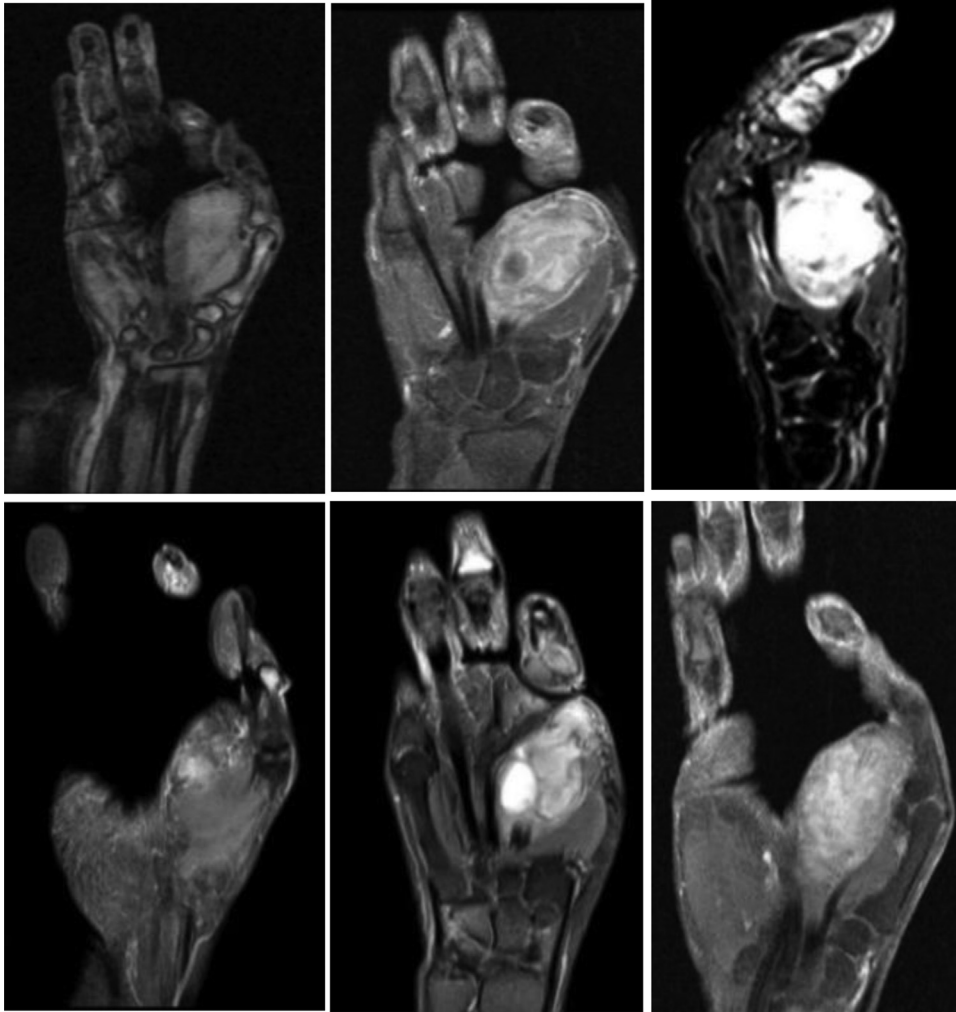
Right palmar MRI sequences: T1W1, T2W1, T1 with contrast and fat saturation, T2 with fat saturation.
